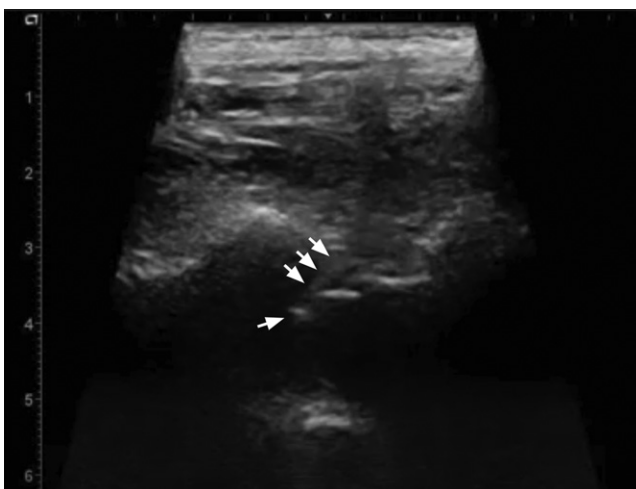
Ultrasound image with access needle and tip confirmation within the thecal space.
